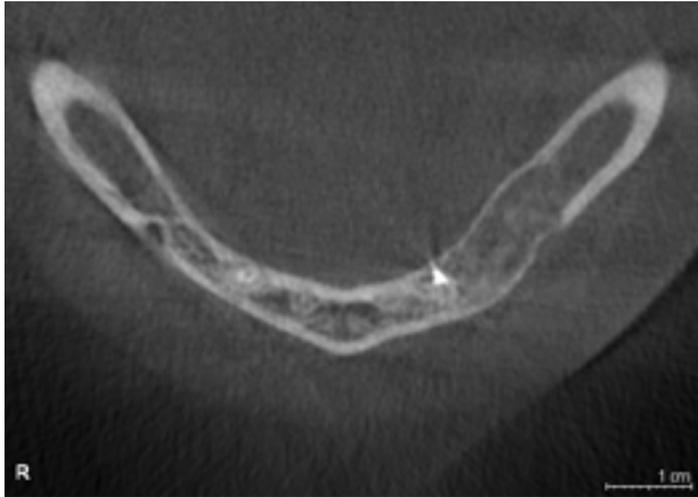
CBCT examination taken 4 months after endodontic treatment revealed significant improvement as the lesion was partly filled with newly woven bone.
